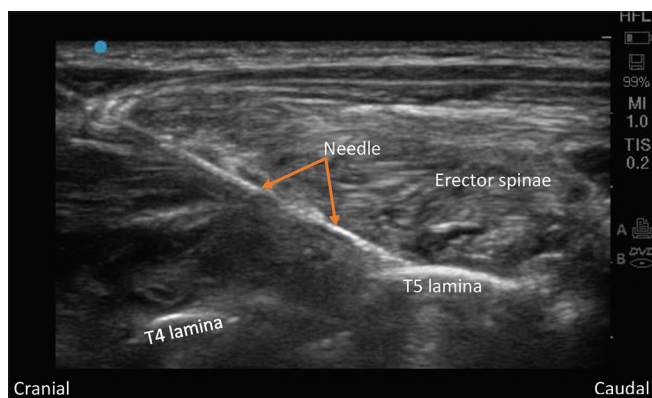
Ultrasound-guided continuous retrolaminar block. Picture shows the entry of a needle, coming into contact with the T5 lamina
